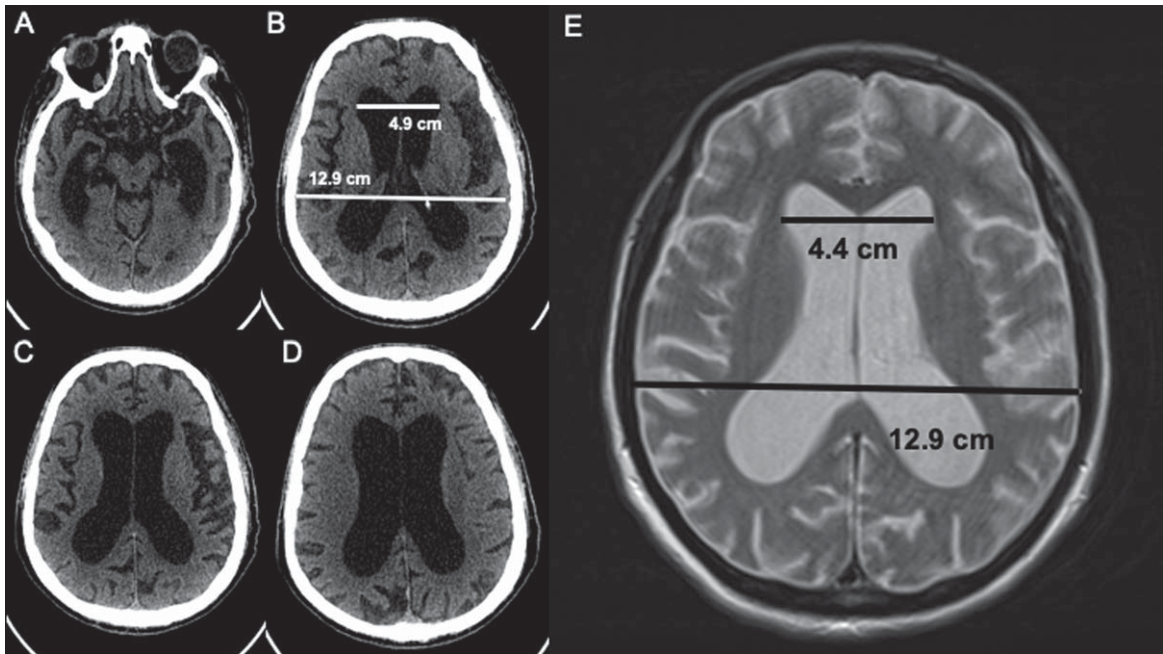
The brain CT scan of Patient 1 (A–D) and brain MRI of Patient 2 (E) shows marked ventricular enlargement. The ration between the width of the anterior horns of the lateral ventricles and the internal diameter of the larger part of the skull (Evans’s ratio) is 0.37 for Patient 1 and 0.34 for Patient 2.
